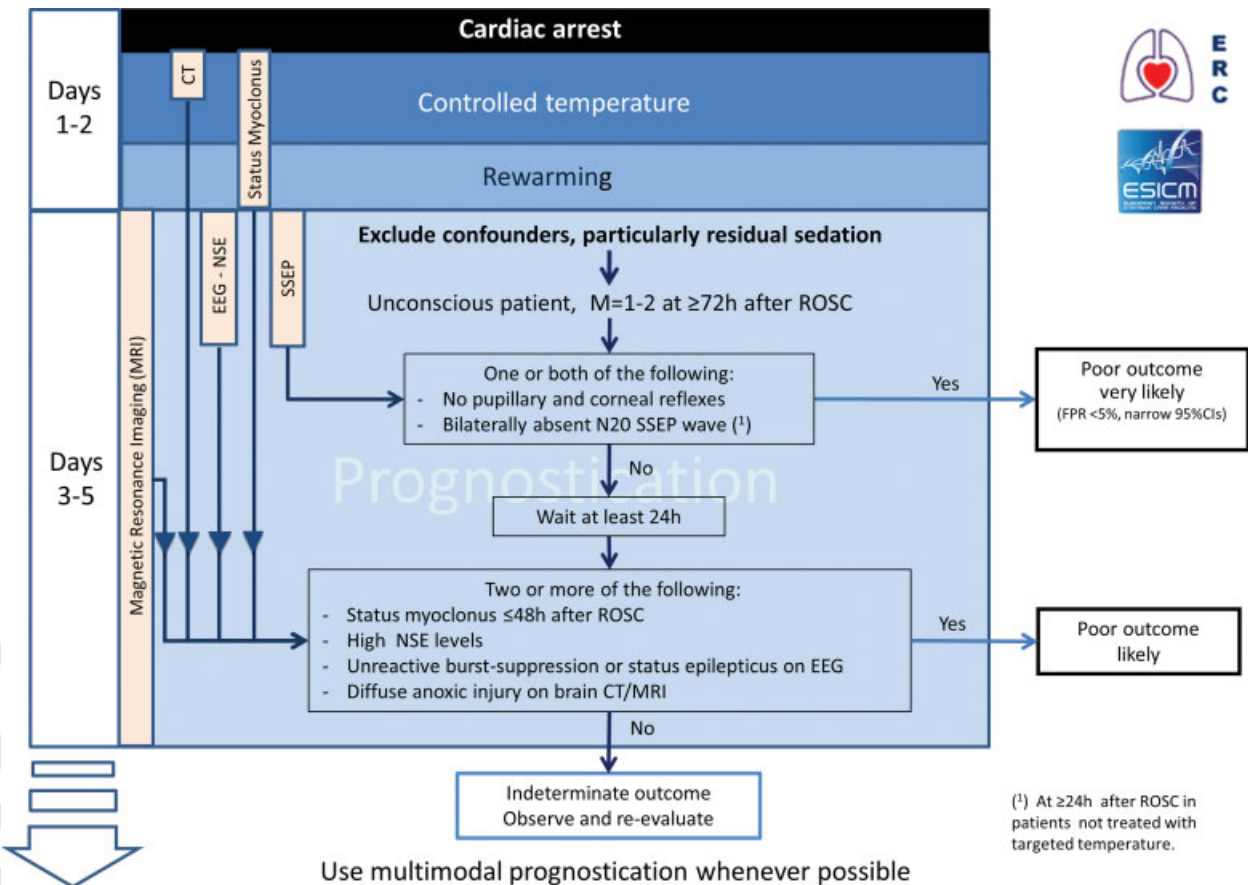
European Resuscitation Council– European Society of Intensive Care Medicine (ERC-ESICM) prognostication algorithm. After the exclusion of confounders, prognostication starts at ≥ 72 hours after recovery of spontaneous circulation (ROSC) in patients who are unconscious with a $M \leq 2$. Bilaterally absent pupillary light response and corneal reflex, or bilaterally absent N20 somatosensory evoked potential (SSEP) waves indicate a poor outcome is very likely. If none of these signs are present, two or more of the following indicate that a poor outcome is likely: status myoclonus ≤ 48 hours, high neuron-specific enolase (NSE) values, unreactive electroencephalography (EEG) with burst suppression or status epilepticus, diffuse anoxic injury on brain computed tomography (CT) and/or magnetic resonance imaging. If none of these criteria are met, the prognosis is indeterminate and prolonged observation with further re-evaluation is indicated. FPR, false-positive rate. (Reproduced from Sandroni et al²².)
